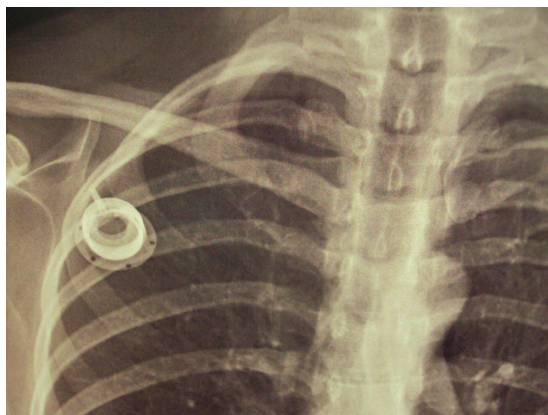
Chest X-ray showing the port without the catheter.
